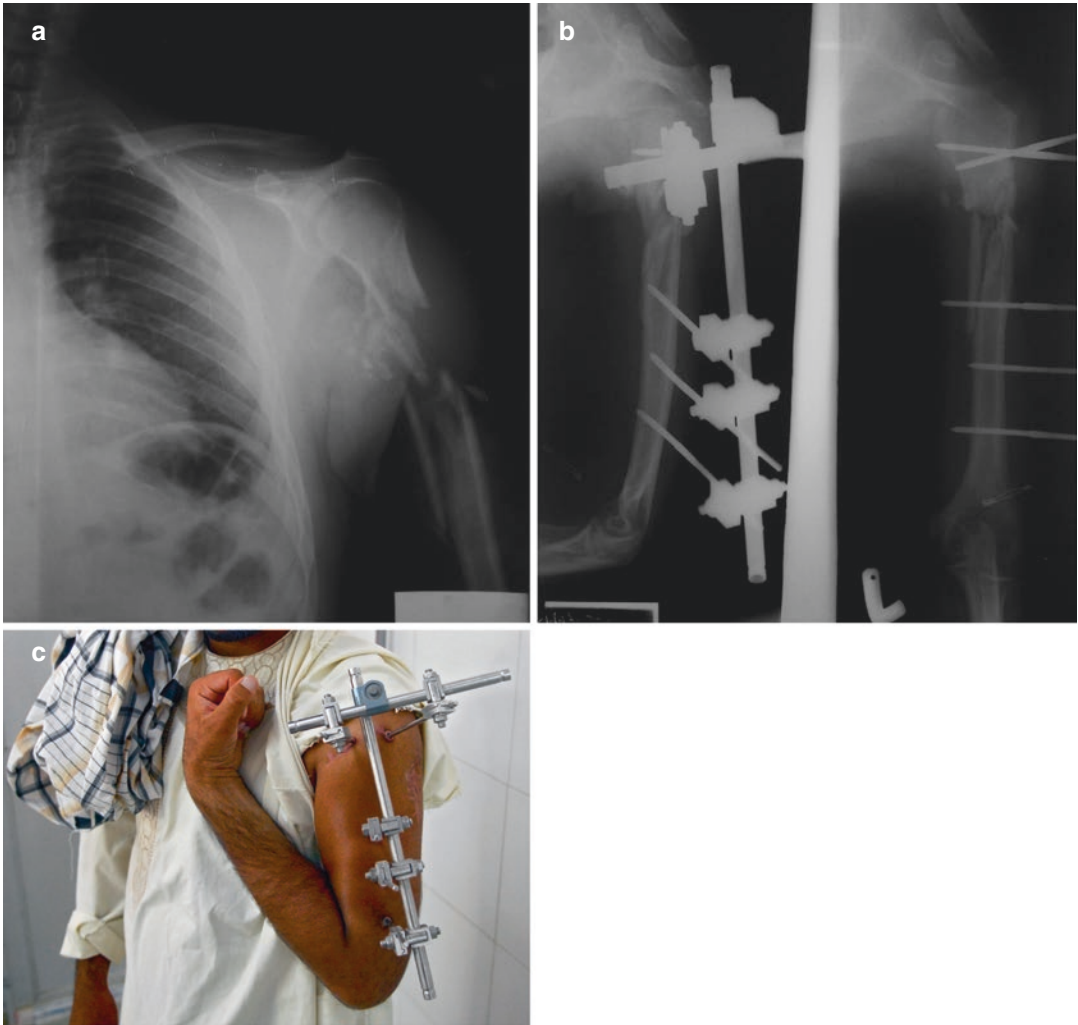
(a) X-ray of GSW proximal left humerus. (b) X-ray with external fixation. (c) Lateral placement of the pins allows near full active elbow flexion
